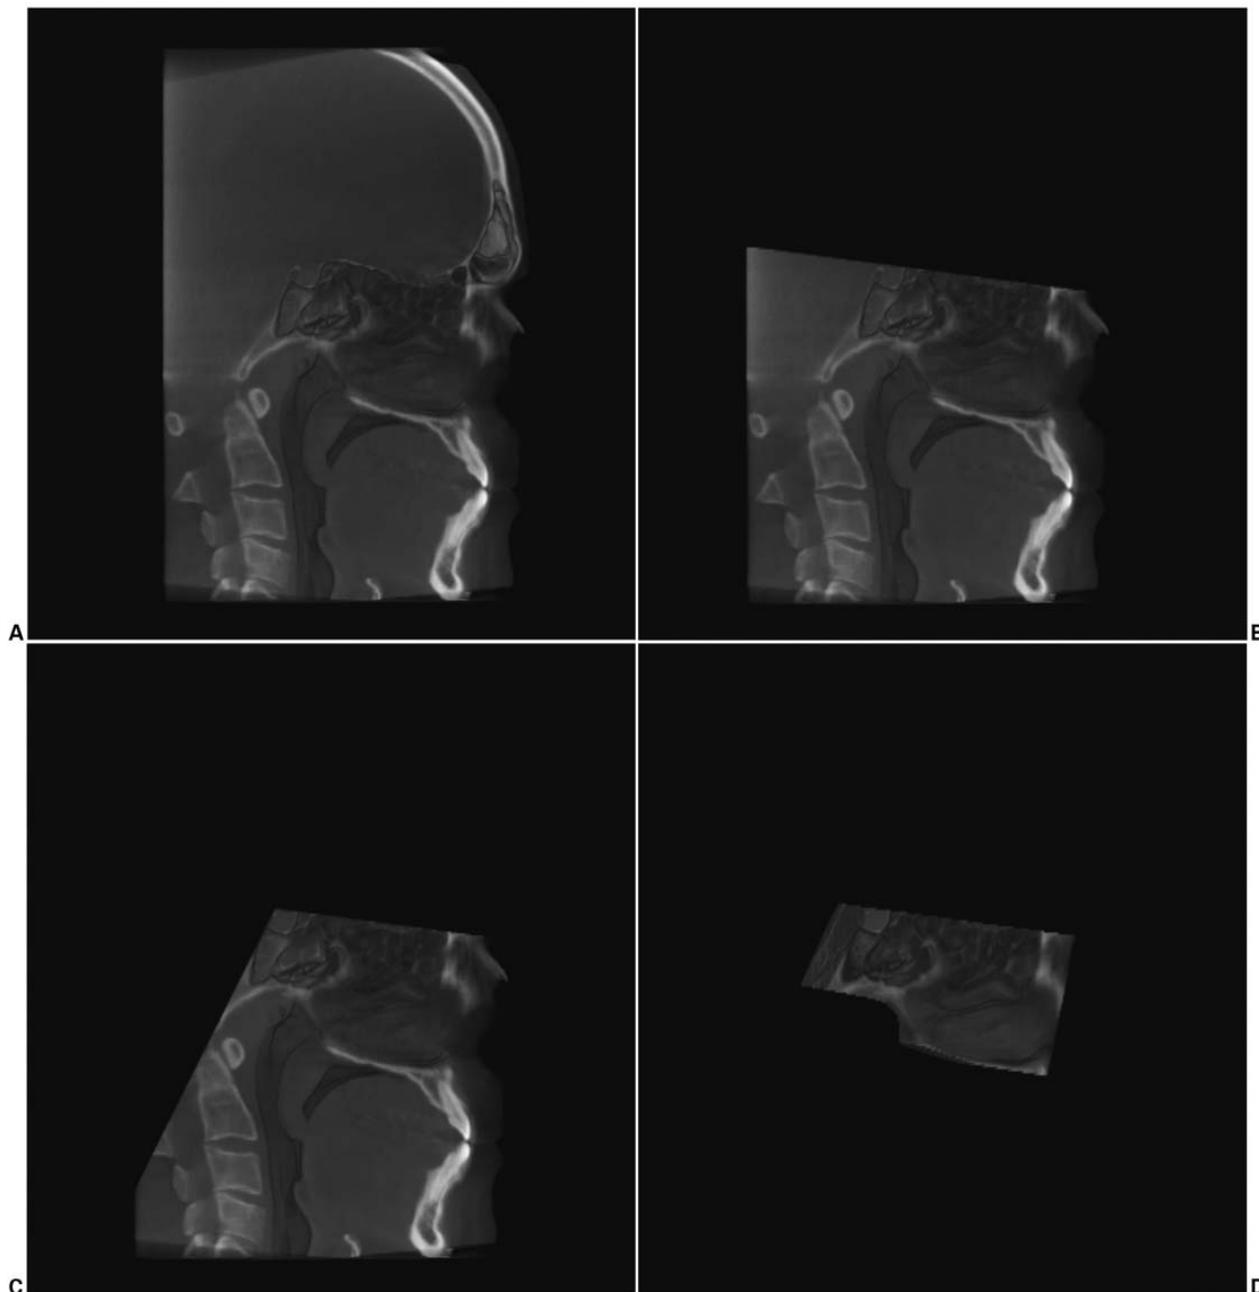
(A) From the 3D CBCT scan data, gray-scale images were used to identify bony landmarks. To acquire the nasal cavity volume, the CBCT scan was trimmed anteriorly from nasion to the anterior nasal spine. (B) The superior aspect of the 3D CBCT image was trimmed from nasion to the most superior part of sella turcica. (C) From the previous 3D CBCT image, the posterior aspect was trimmed from the most superior point of the sella turcica to basion. (D) The inferior aspect of the 3D CBCT image was trimmed following the hard palate. This procedure was followed systematically for each pre-treatment and post-treatment volume, leaving only the nasal cavity for volumetric analysis.
